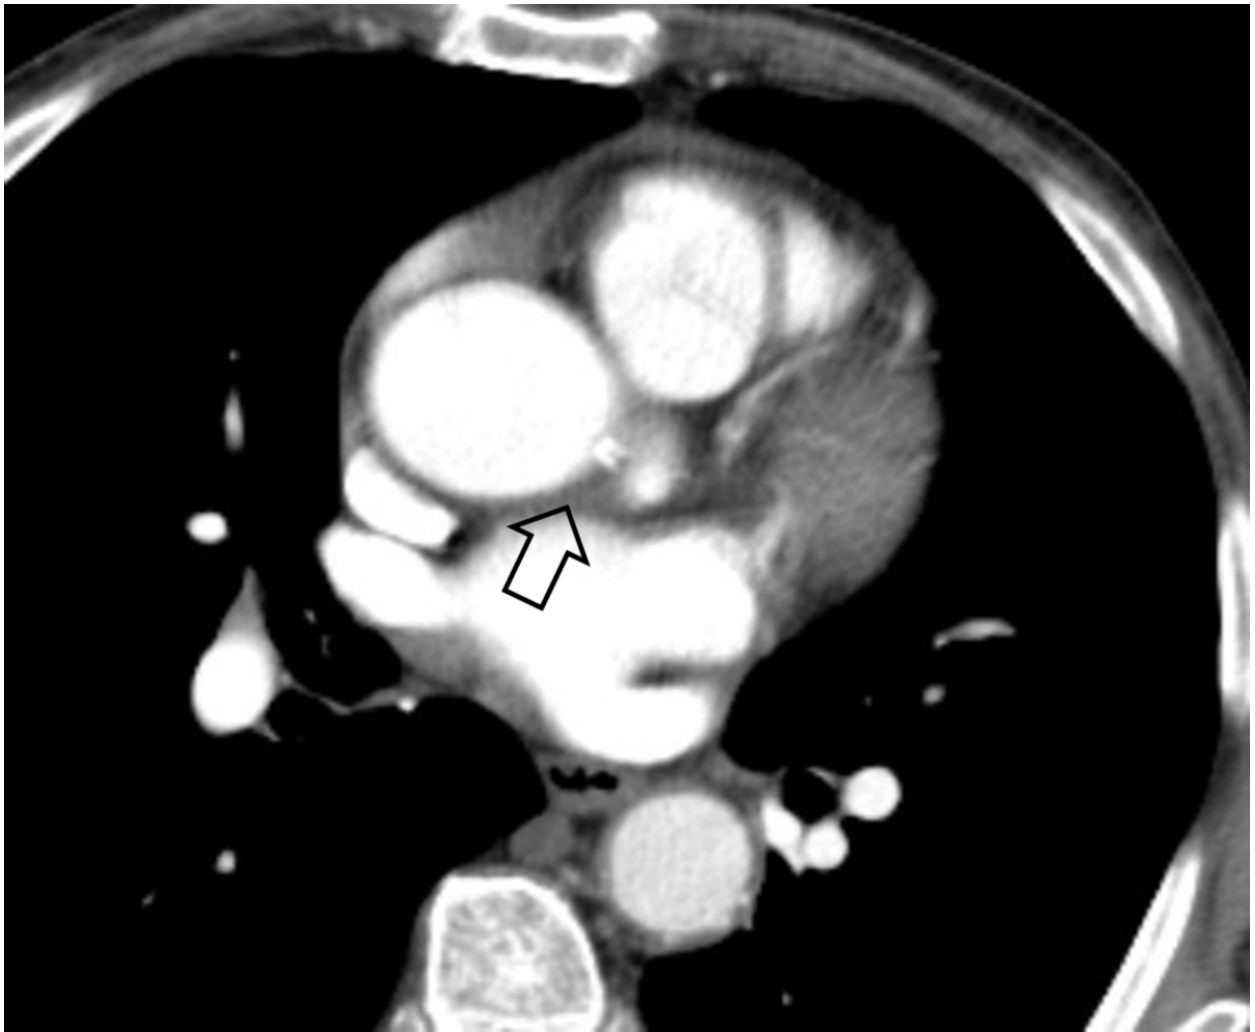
Axial CT image showing the location of the inferior aortic recess (white arrow).
